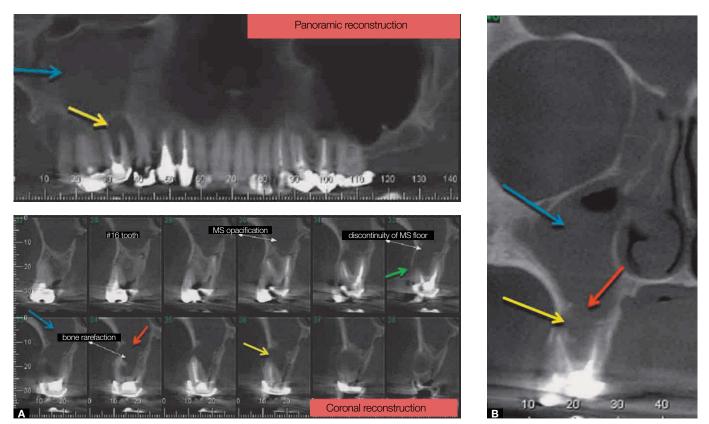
A) Panoramic reconstruction and cross section: Note bone rarefaction in the periapical and furca region of #16 tooth, compatible with osteolytic lesion of inflammatory/infectious origin. B) Coronal reconstruction: discontinuity of the vestibular cortical of the alveolar process and maxillary sinus (MS) floor.
